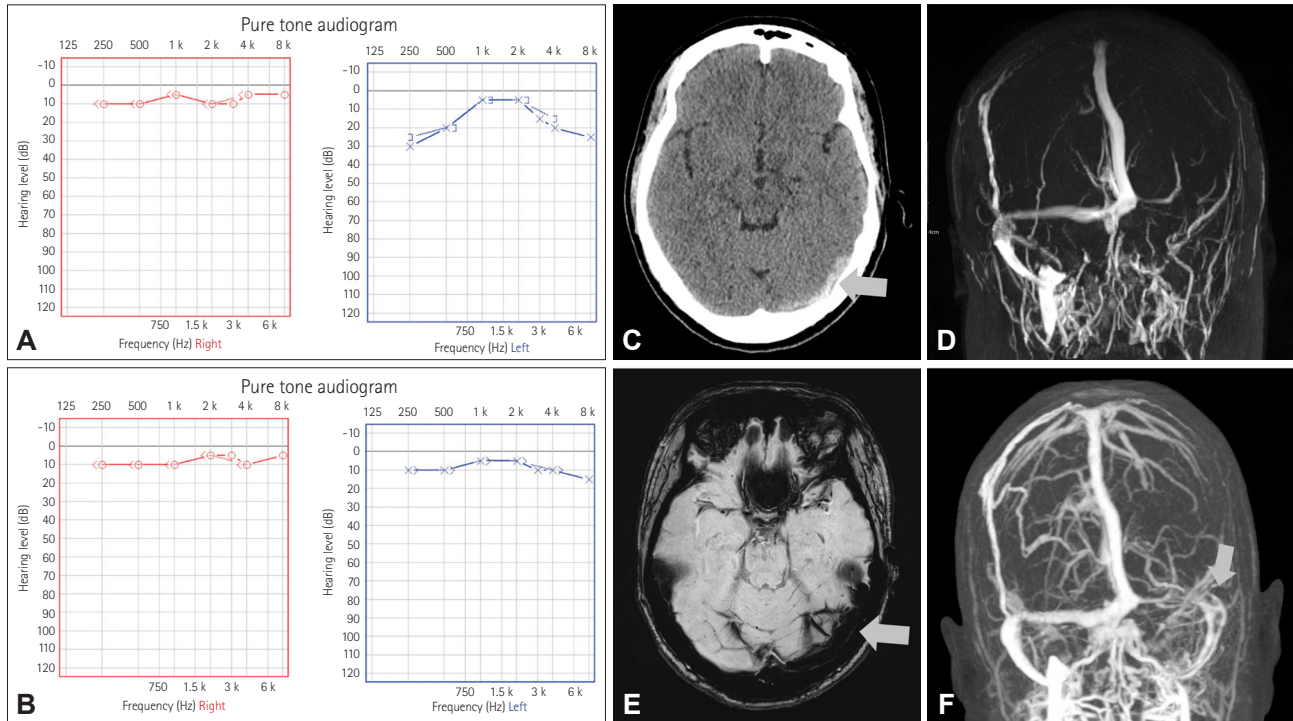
No visualization of left transverse sinus, sigmoid sinus, or distal internal jugular vein, indicating probable dural venous sinus thrombosis. A, B : Pure-tone audiometry was conducted during the ictal period (A) and after the resolution of vestibulocochlear symptoms (B). C : Hyperattenuation in the left transverse sinus (arrow) in nonenhanced brain CT. D : Probable dural venous sinus thrombosis in time-of-flight MR venography. E: Blooming artifact in the left transverse sinus (arrow) in susceptibility-weighted MRI. F: Decreased burden of cerebral venous thrombosis in the left transverse sinus is re-vealed (arrow) in the CT venography performed 3 months after discharge.
